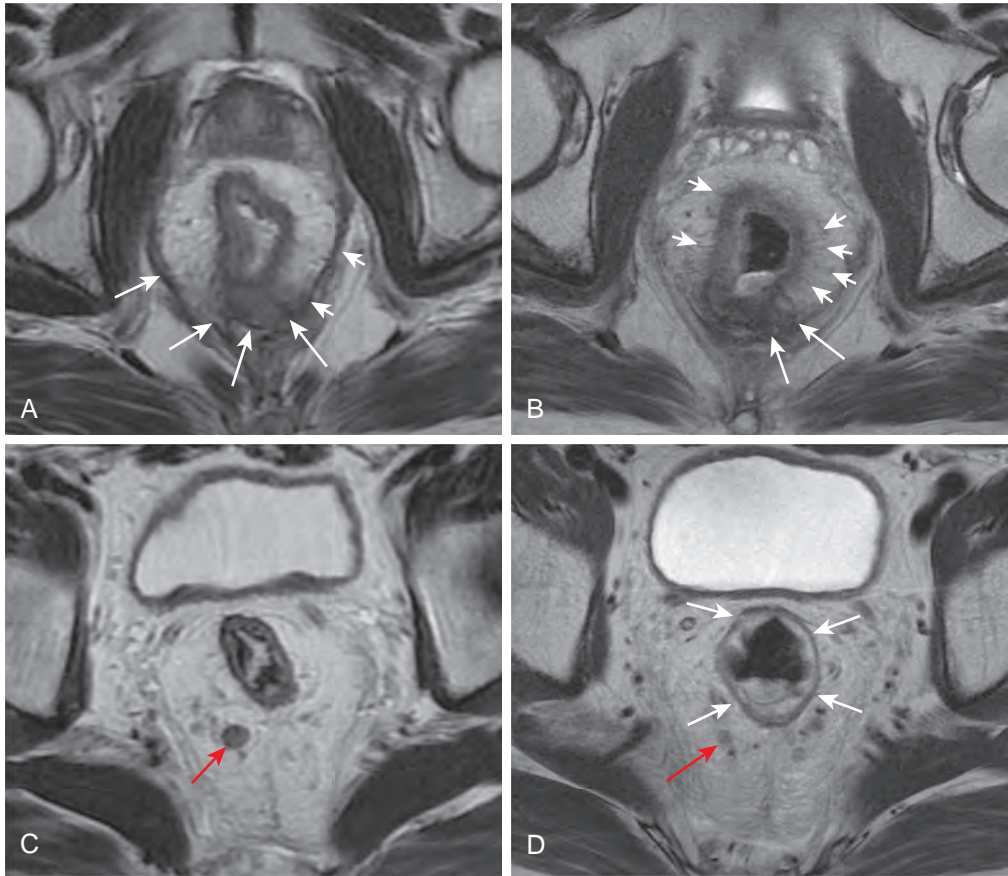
MRI scans of rectal adenocarcinoma with extension to mesorectal fascia (T3N2M0) before and after neoadjuvant chemotherapy and radiation). A. This T2-weighted MRI scan demonstrates rectal wall thickening with the tumor extending posteriorly beyond the rectal wall (long arrows) and reaching the mesorectal fascia (short arrows), which is well shown in this view. B. Following treatment, the rectal wall is less defined on this high-resolution MRI scan and shows multiple thin spicules (short arrows) extending from the rectal wall into the perirectal fat. This represents acute radiation change and not tumor extension. Posteriorly, the tumor extension to the mesorectal fascia (long arrows) is still present but slightly reduced compared to image A. C. Axial T2-weighted MRI scan demonstrates an enlarged round perirectal node (red arrow). D. Following neoadjuvant chemotherapy and radiation, an axial T2-weighted MRI scan close to the same level as C shows the same node (red arrow), which now is considerably smaller. Note the edema in the rectal wall (long arrows) above the tumor following radiation.
